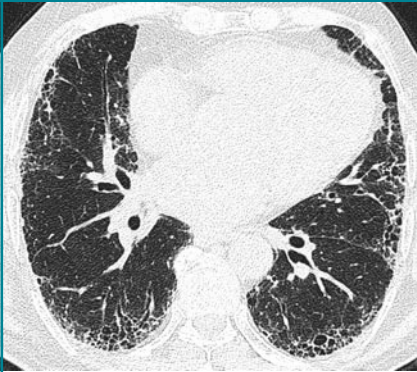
Transverse CT scan shows basal and subpleural honeycombing, indicative of usual interstitial pneumonia.
